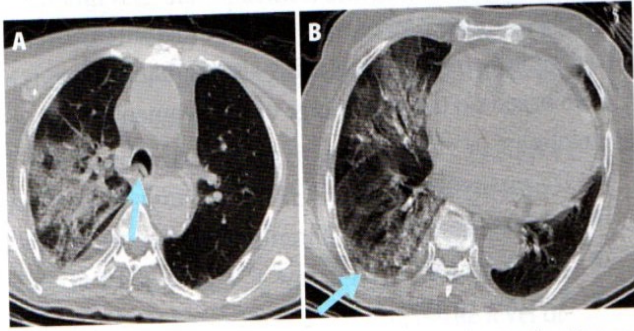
A 72-year-old man with a history of cardiovascular disease and diabetes had a positive RT-PCR test. He died in the intensive care unit after 11 days of treatment. Because of movement artifacts and insufficient inspiration, distinguishing between the healthy and the involved parenchyma was difficult, which led to disagreements among the readers on the CT severity score (CT-SS). A. Axial lung window of noncontrast chest CT shows the bowing forward of the trachea's posterior wall because of insufficient inspiration (arrow). Extensive consolidations, ground-glass opacities (GGOs), and crazy-paving pattern are seen in the upper lobe of the right lung. B. In lower sections, chest CT shows consolidations, GGOs, and crazy-paving pattern in the middle and lower lobe of the right lung. Shading (arrow) occurred near consolidations and GGOs because of motion artifacts. Images courtesy of the authors.
